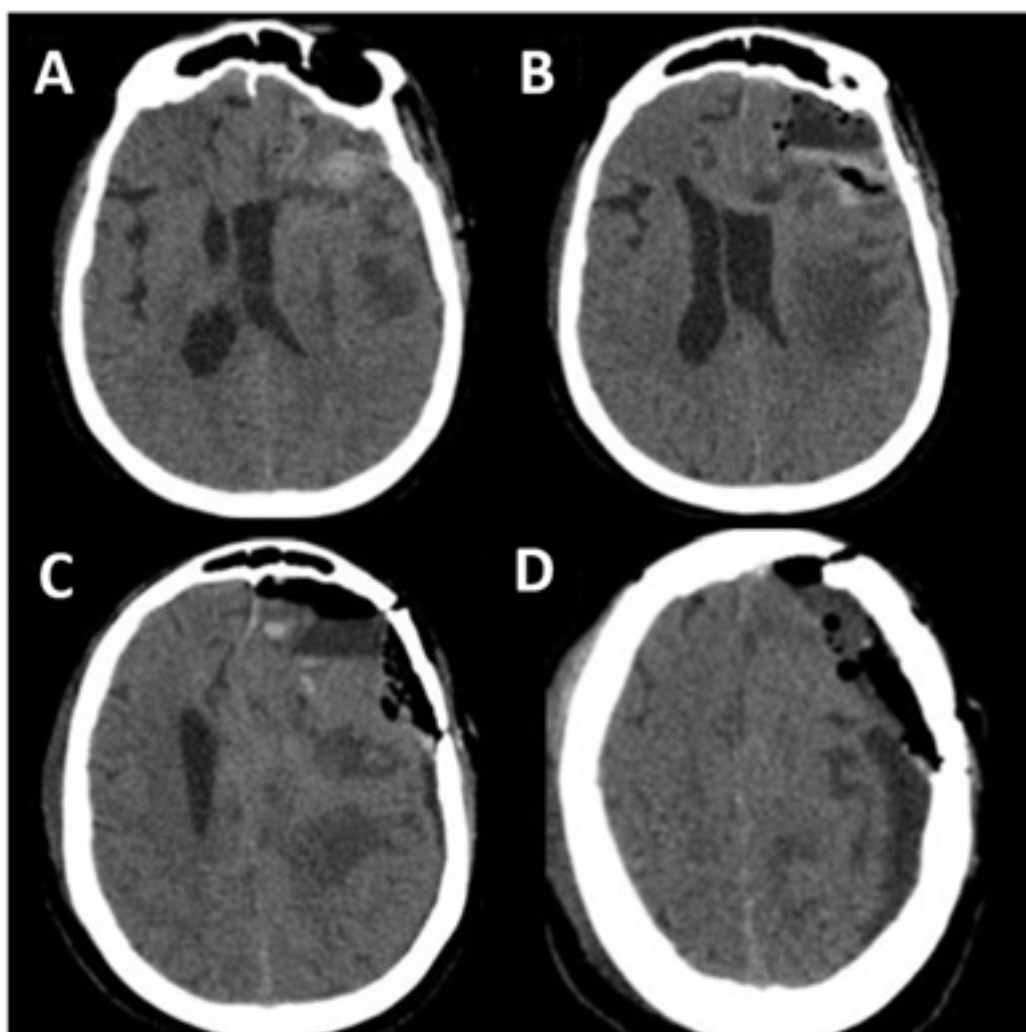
A-D. CT in axial sections showing the area of surgical resection, with no evidence of postoperative complications.
